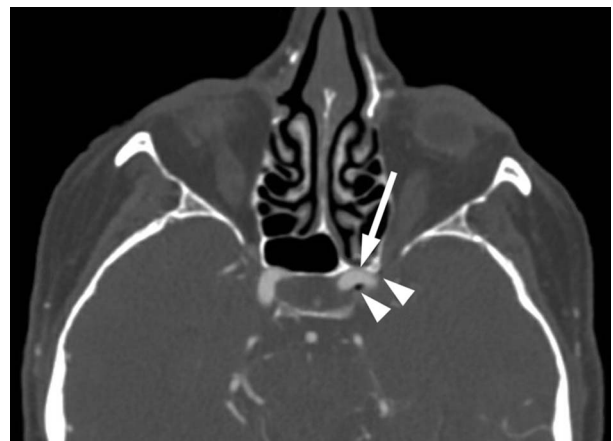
Computed tomography scan demonstrating air bubble around the ICA (between arrowheads), with dehiscence of the lateral wall of the sphenoid sinus (arrow).
